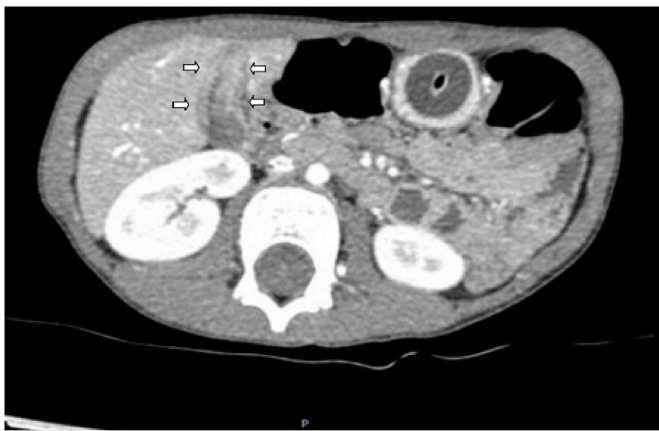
CT scan shows thickened gallbladder walls (white arrows) and absence of gallbladder polyps.
